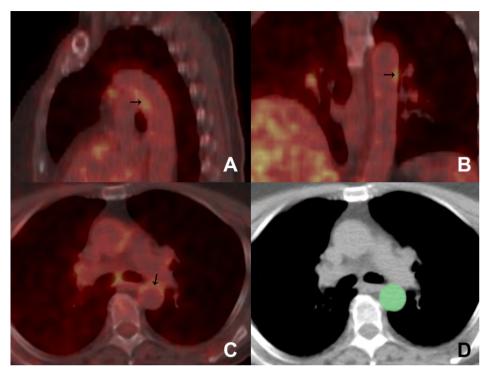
Example of a hotspot in the descending aorta on ¹⁸F-FDG-PET/CTi mages Arrows indicate hotspot in descending aorta on (A) sagittal (B) coronal and (C) trans axial fused PET/CT images. An example of a region of interest (ROI) is depicted in green on (D) trans axial CT image.
